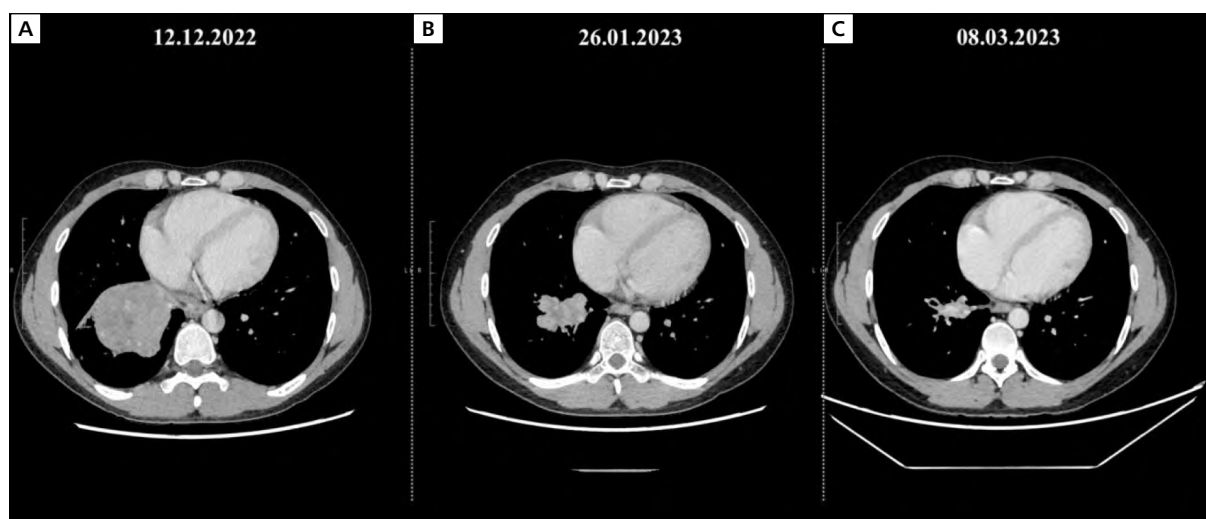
Regression of the tumor shown in three consecutive computed tomography scans
